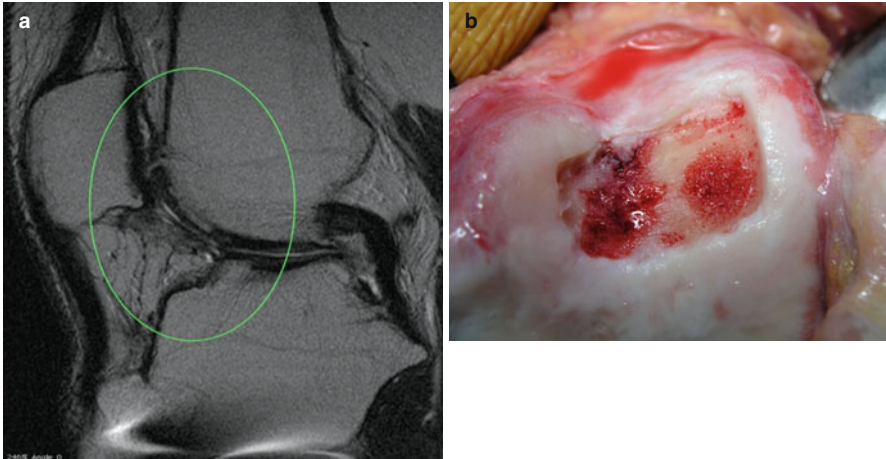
(a) MRI scan of an intralesional osteophyte of the trochlea (*left*) and (b) intraoperative picture after debridement (*right*). Note the abnormal appearance of the subchondral bone and the holes from the previous microfractures
